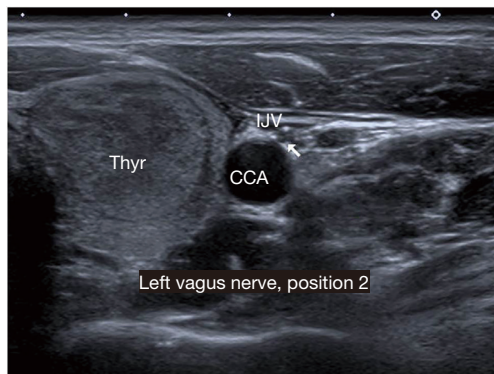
Ultrasound aspect of the left vagus nerve (white arrow) in position 2. THYR, thyroid lobe; IJV, internal jugular vein; CCA, common carotid artery.
